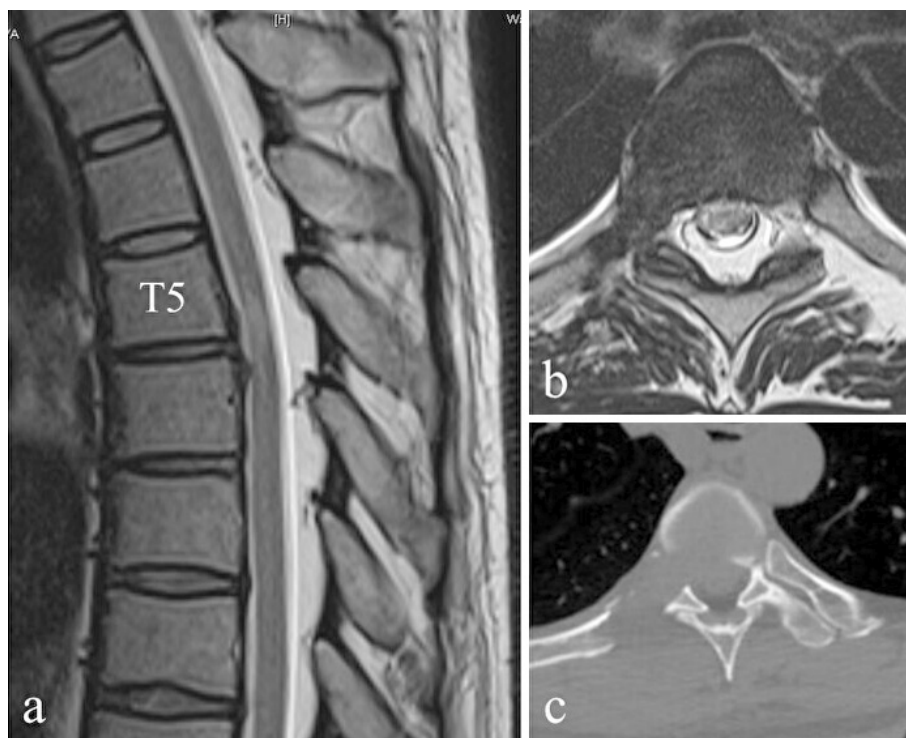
Postoperative magnetic resonance images show adequate removal of the herniation (a, b), and computed tomography shows bone resection on the preoperatively planned course with almost complete preservation of the right facet joint (c).
